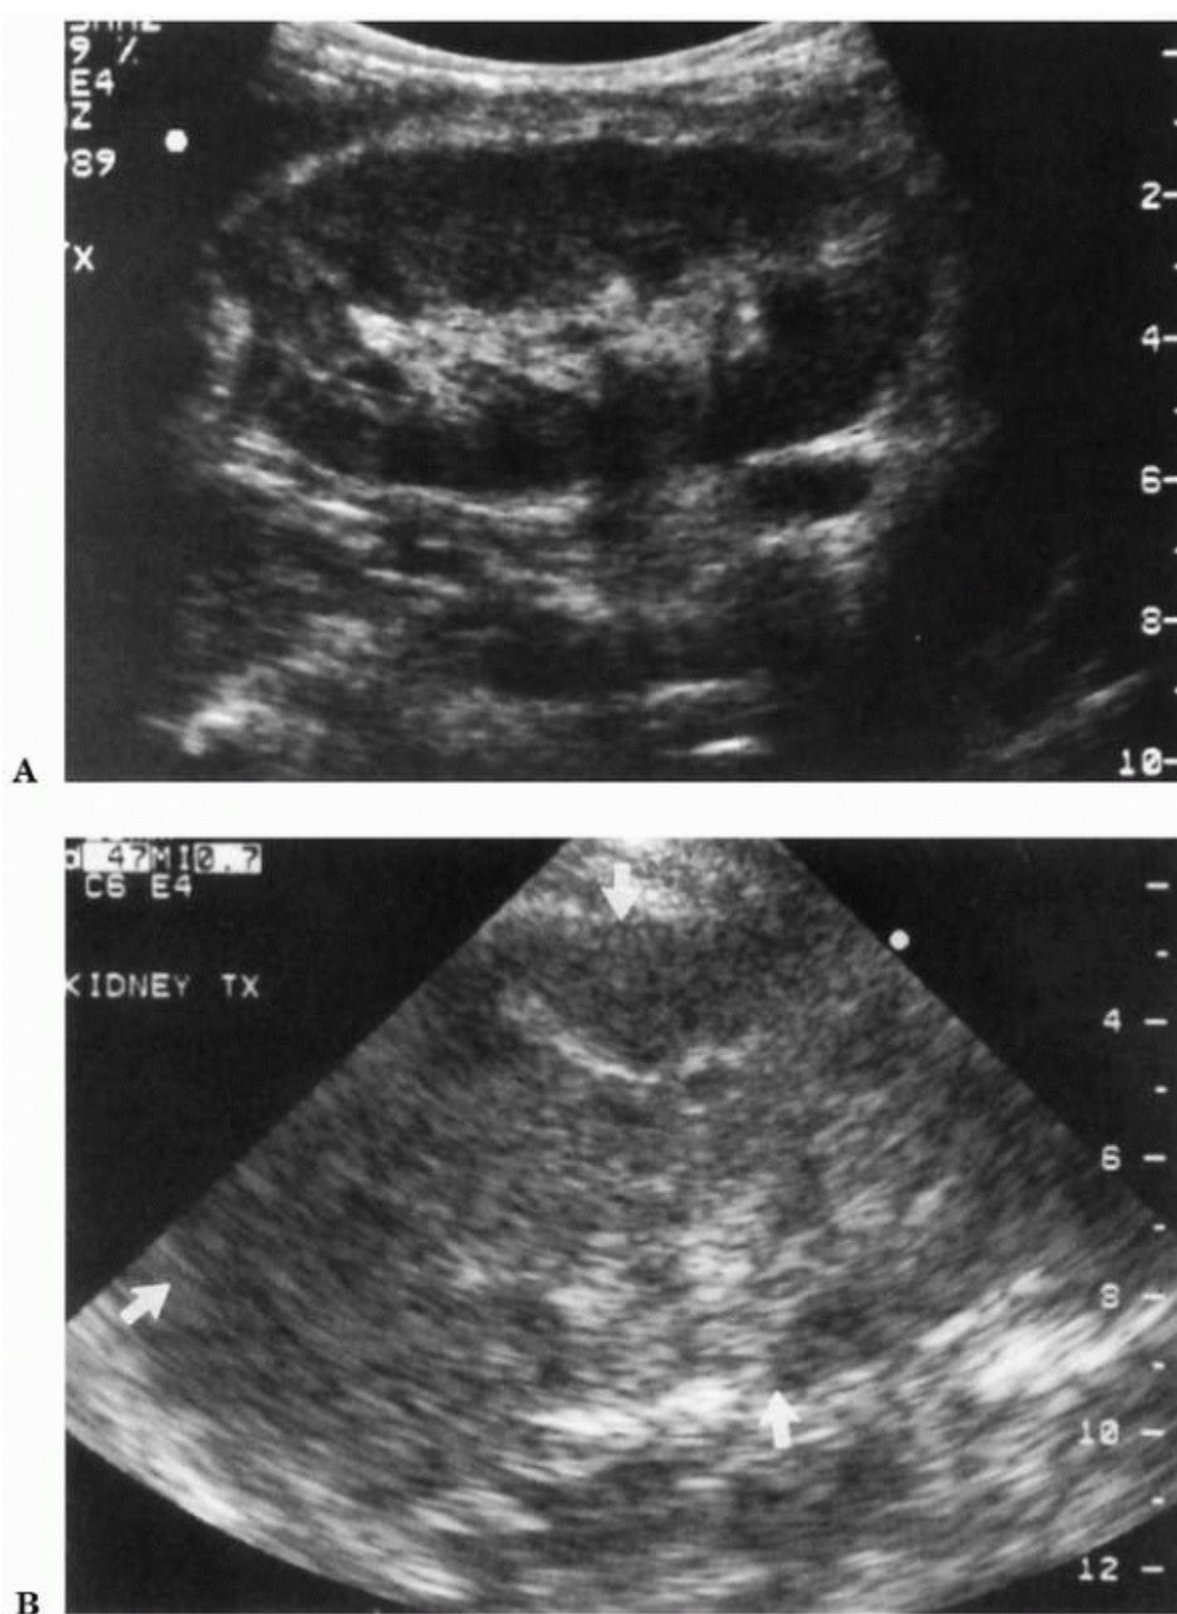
A: Sonogram of normal transplant kidney. B: Sonogram of transplant undergoing rejection reveals graft enlargement, decreased echogenicity of renal sinus (compare to echogenic sinus in A) and obscured corticomedullary delineations. Margins of graft are marked by *arrows*.
